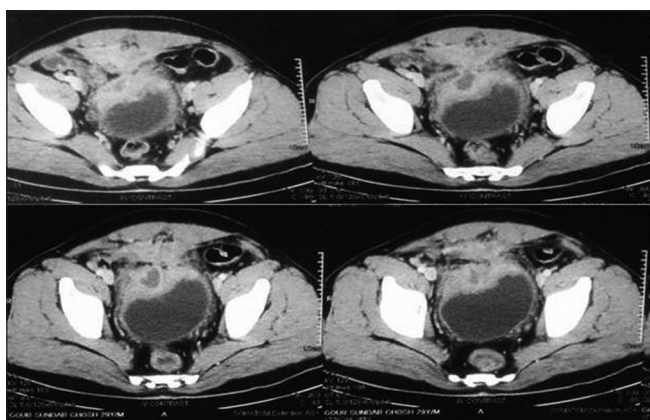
Contrast-enhanced computed tomography scan revealing an irregular enhancing mass lesion with central hypodense area situated in hypogastric area, abutting the superior wall of bladder with thickened bladder wall
